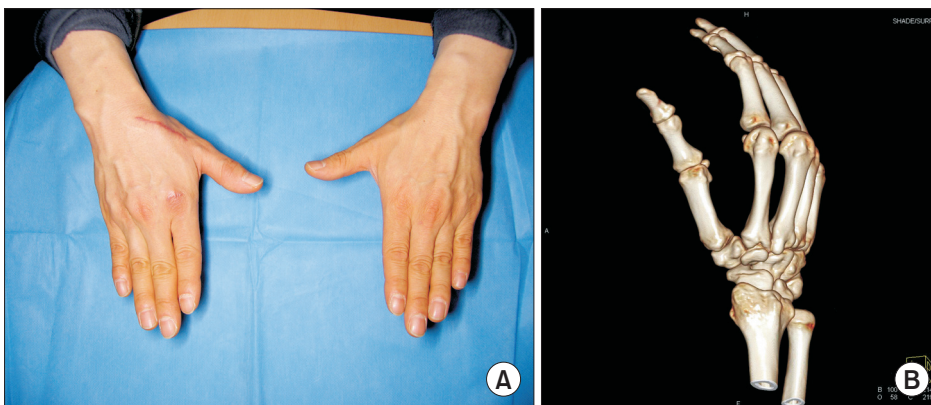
Three months after the operation, the patient was examined in the outpatient clinic. The patient was allowed full extension of the right thumb (A) and there was no recurrence of the osteophyte at the carpometacarpal joint of the thumb on computed tomography of the right wrist (B).
